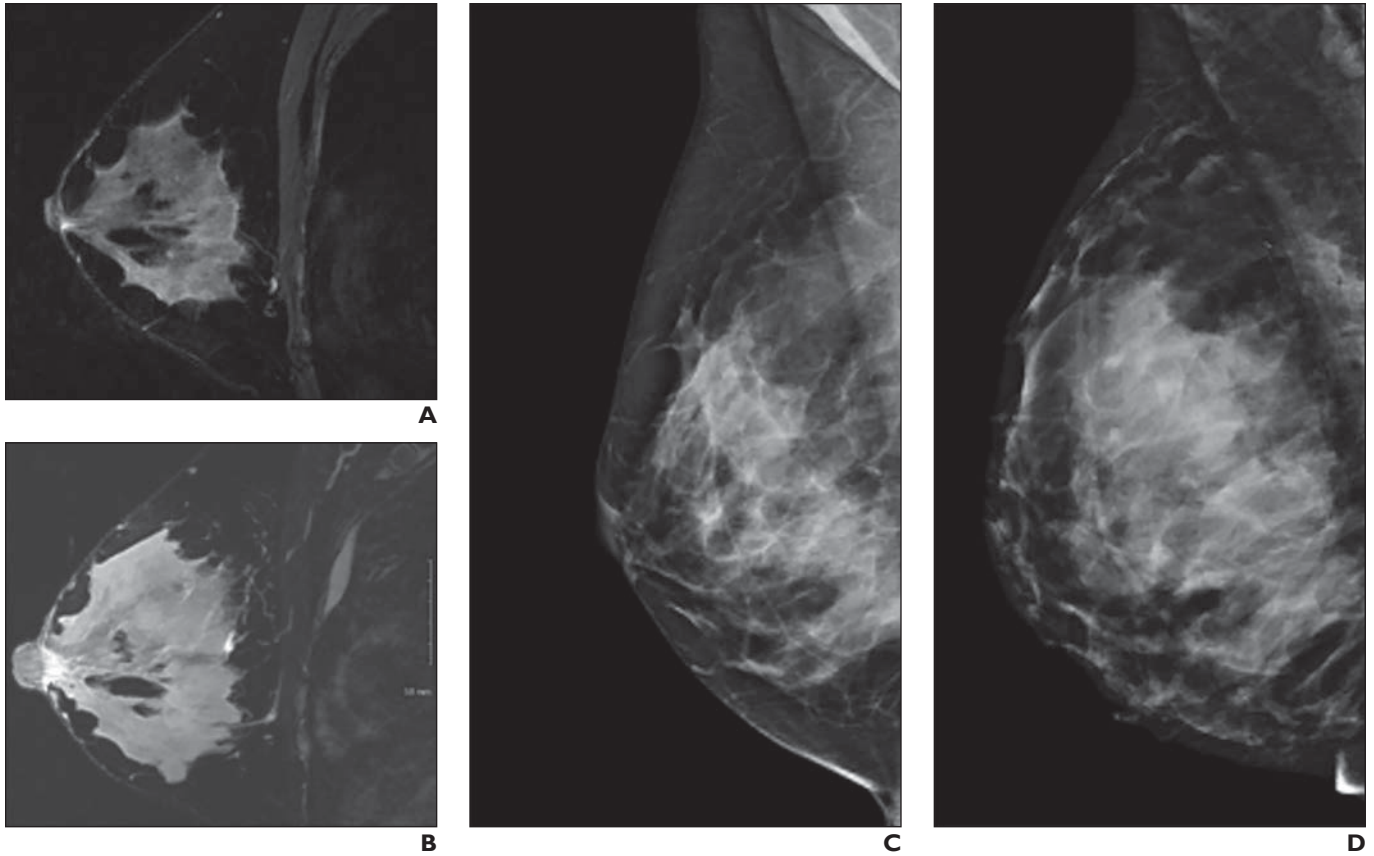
31-year-old woman who presented for high-risk screening MRI and screening mammography before lactation and during lactation. A and B, T2-weighted MR images of right breast before lactation (A) and during lactation (B). C and D, Mediolateral oblique screening mammograms of right breast before lactation (C) and during lactation (D). Notice marked ductal sprouting, lobular growth, and relative decrease in breast fat resulting in overall increase in breast size and density during lactation.
